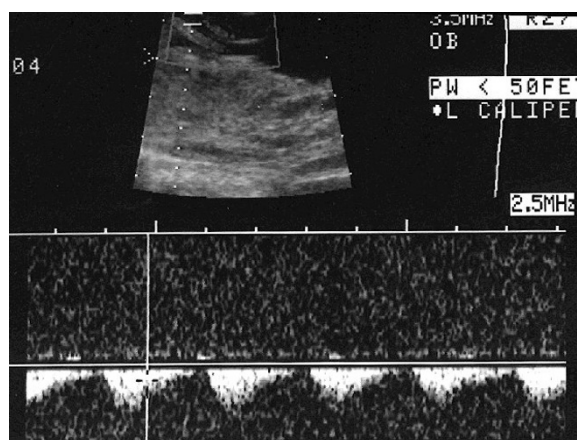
Abnormal umbilical artery Doppler wave form with absent diastolic flow in a growth-restricted fetus at 34 weeks' gestation
